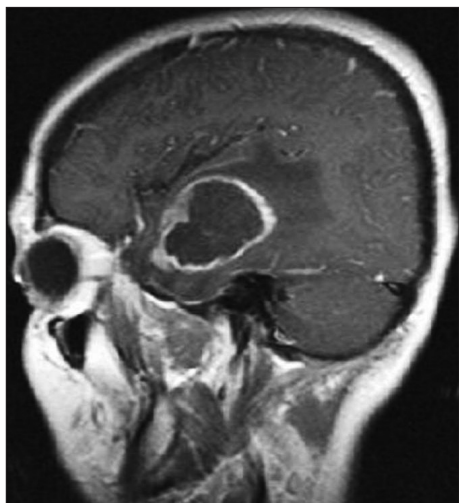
Preoperative sagittal MRI scan showing left temporal lobe glioblastoma multiforme.
